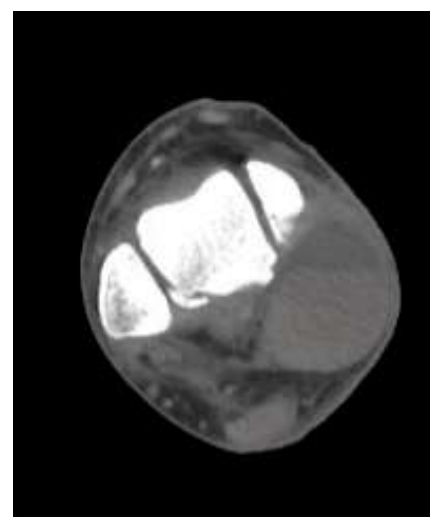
Angio-CT examination in axial cut. Note on the right the tumefaction coinciding with the vascular lesion.
